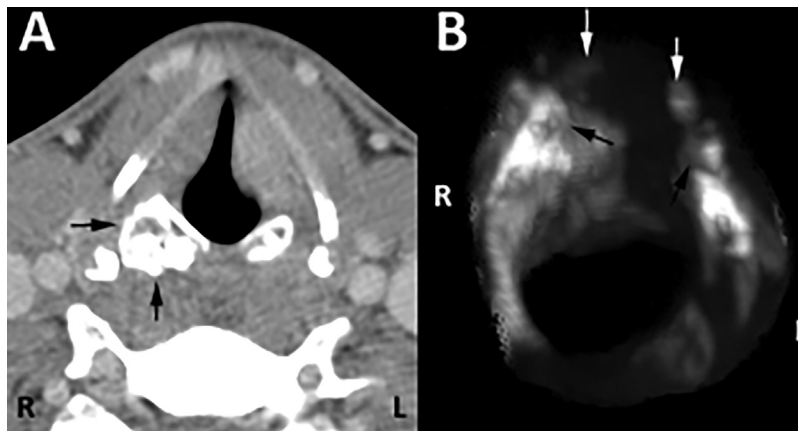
Preoperative CT scan and computer generated three-dimensional reconstruction images. (A) Axial CT image showing severe ossification (black arrows) in the lamina of the cricoid cartilage at the level of vocal folds. (B) Left antero-superior oblique three-dimensional reconstruction view of the larynx without the thyroid cartilage showing severe ossification in the lamina of the cricoid cartilage and the right cricoarytenoid joint. The left cricoarytenoid joint is normal. White arrows indicate the apex of bilateral arytenoid cartilages. Black arrows indicate bilateral cricoarytenoid joints.
